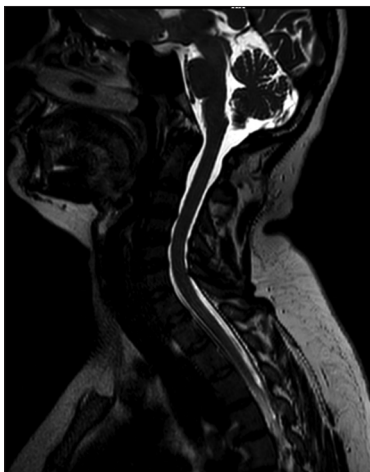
Magnetic resonance imaging cervical spine taken after 3 months showed complete disappearance of the lesion with treatment
